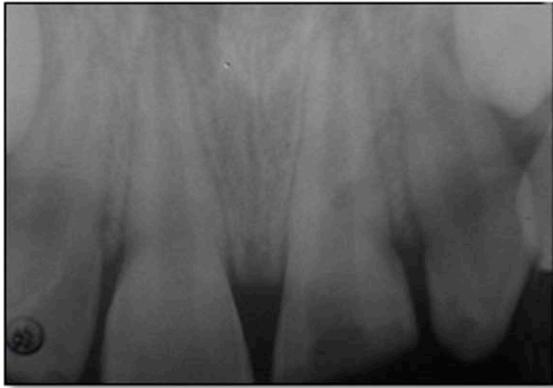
Pretreatment periapical radiograph of the fractured maxillary left central incisor (tooth 21).
